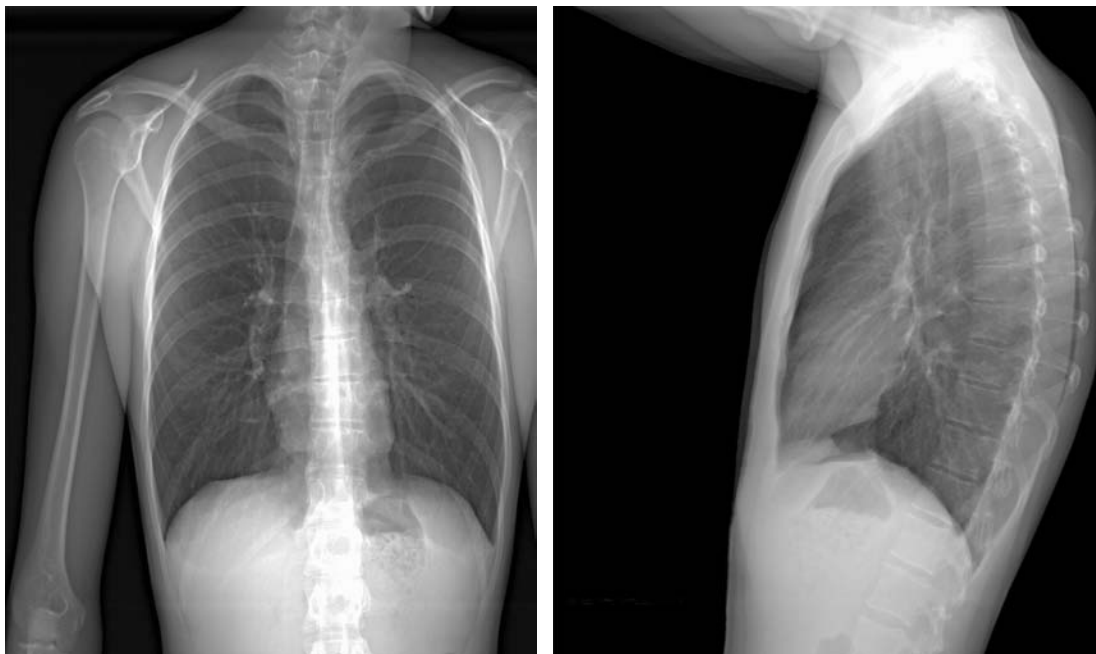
19-year-old Female. EOS acquired radiography.
